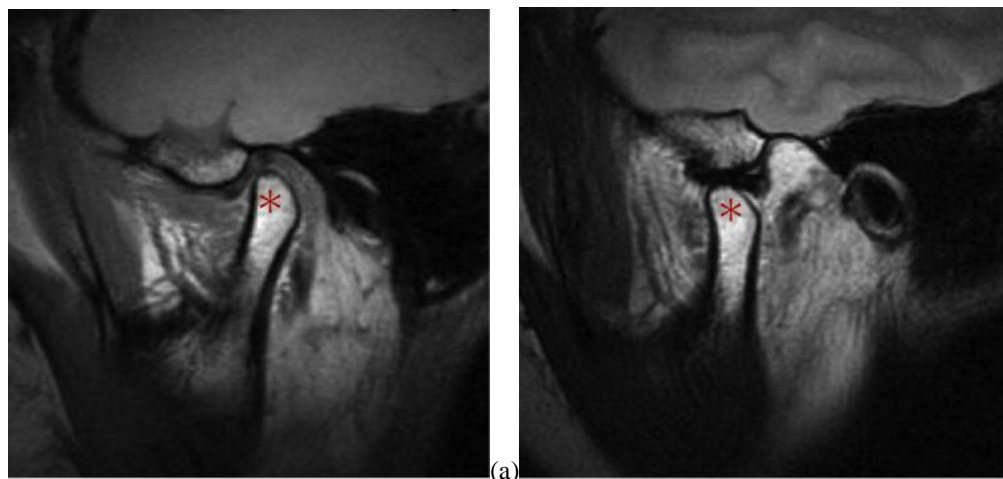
(a) Oblique sagittal T1-weighted image of the left TMJ in the closed mouth position showing that the articular disk has normal biconcave appearance and disk position. (b) Oblique sagittal T2-weighted image of the left TMJ in the open mouth position showing normal anterior translation of the condyle(asterisk) and little JE within the joint compartments.
